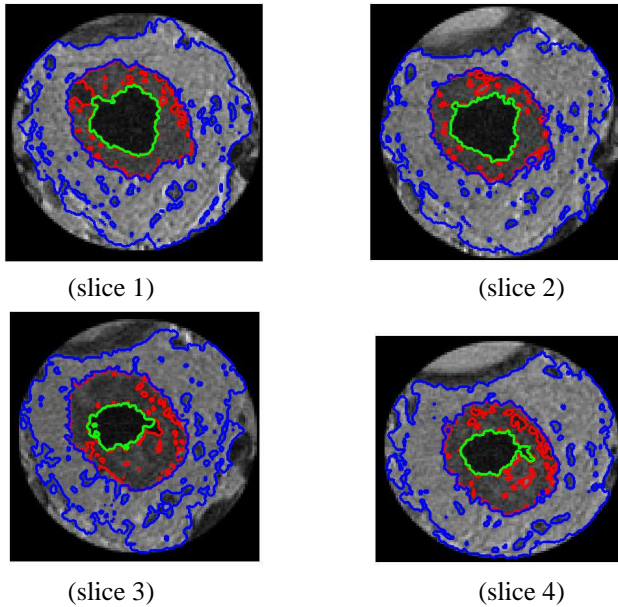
Level set segmentation of four colorectal MR image slices using NPMM-ICLS algorithm. Colour code: green - colorectum, red - tumour, blue - mesorectum.
